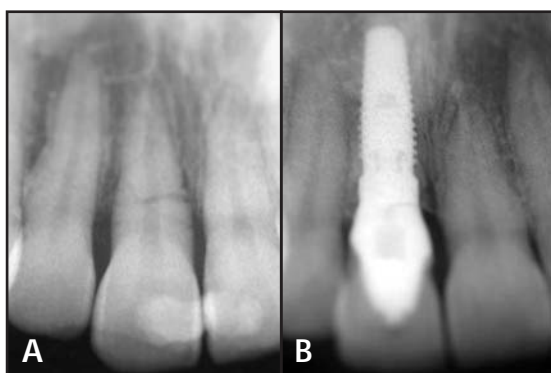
Preoperative radiograph of the fractured incisor. 13B. Postoperative radiograph 1 year following restoration demonstrated crown adaptation and maintenance of the bone levels around the implant.
